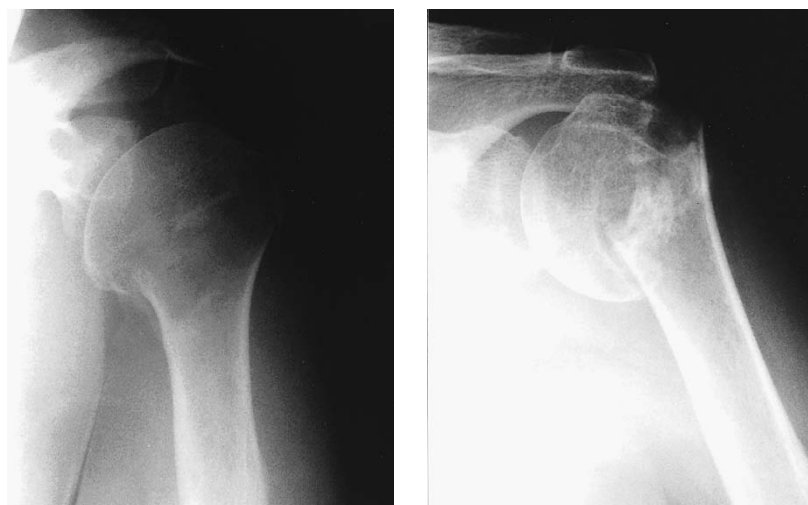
Antero-posterior radiographs of a 73-year-old woman who initially showed very little evidence of varus (A). However 6 weeks later there was a considerable increase in varus angulation (B).
